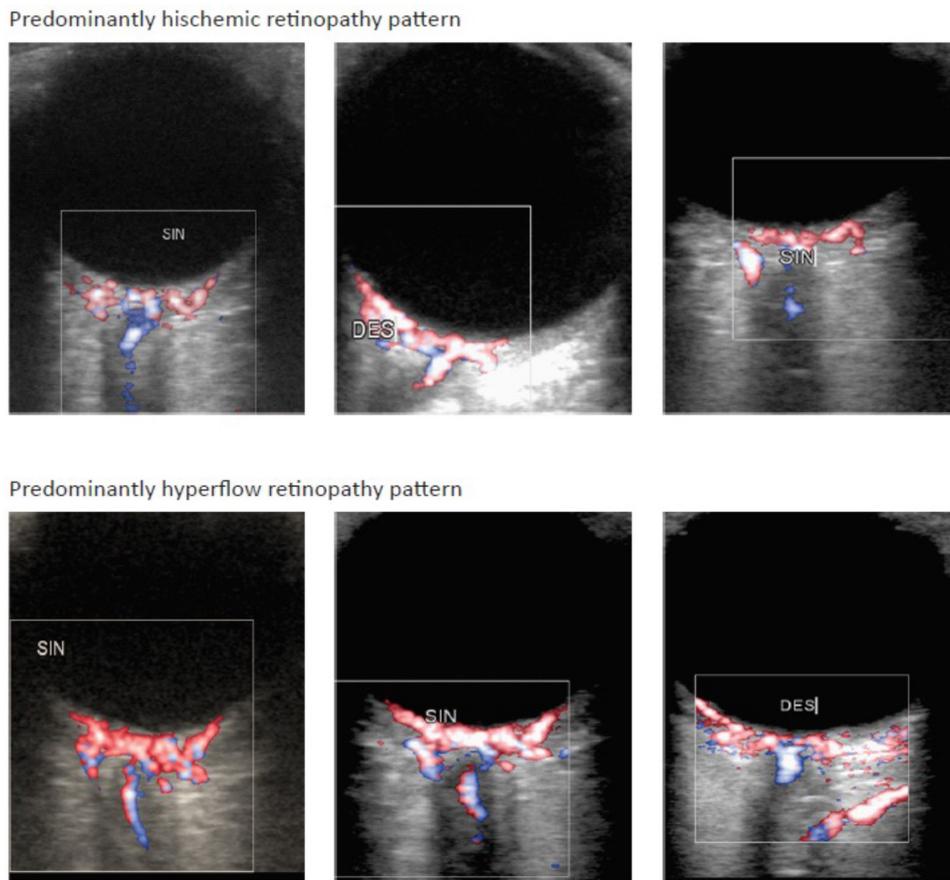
Orbital colour Doppler imaging. Left and right eyes color Doppler ultrasonography of the central retinal vein and artery at their emergence from the optic nerve showing predominantly hischemic retinopathy patterns in the top panel, and predominantly hyperflow retinopathy pattern in the bottom panel.
